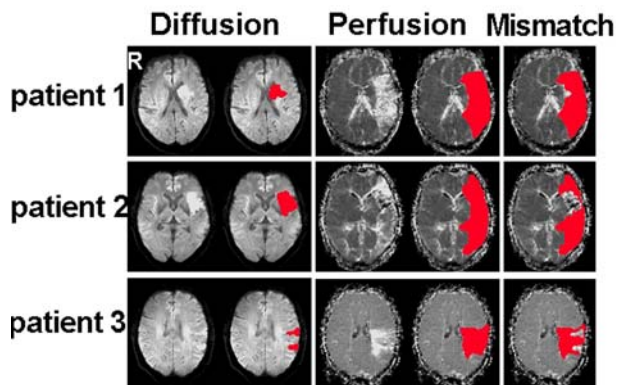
Infarct core (from DWI), hypoperfusion area (MTT map from PWI) and mismatch areas (PWI – DWI) of three patients.
